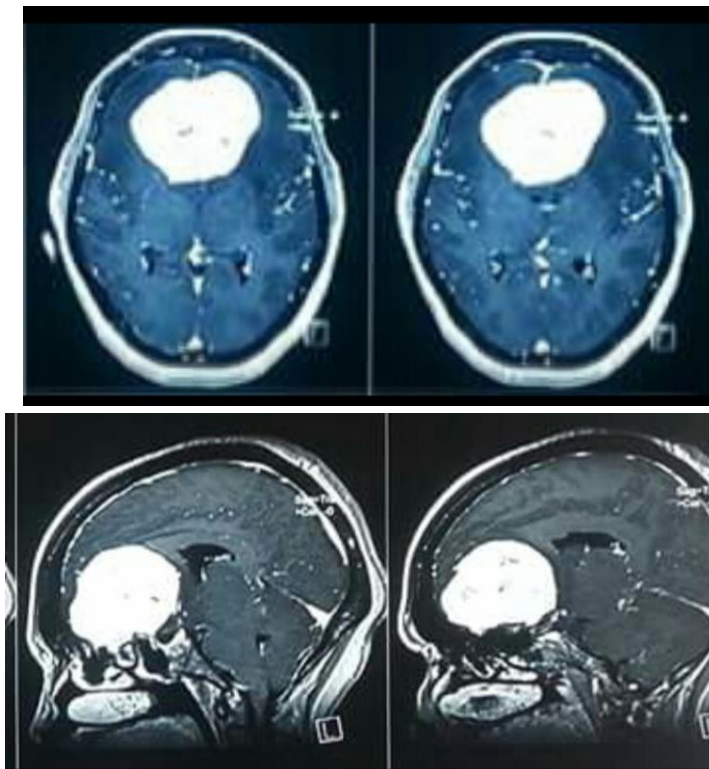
a): Preoperative MRI showing olfactory groove meningioma
